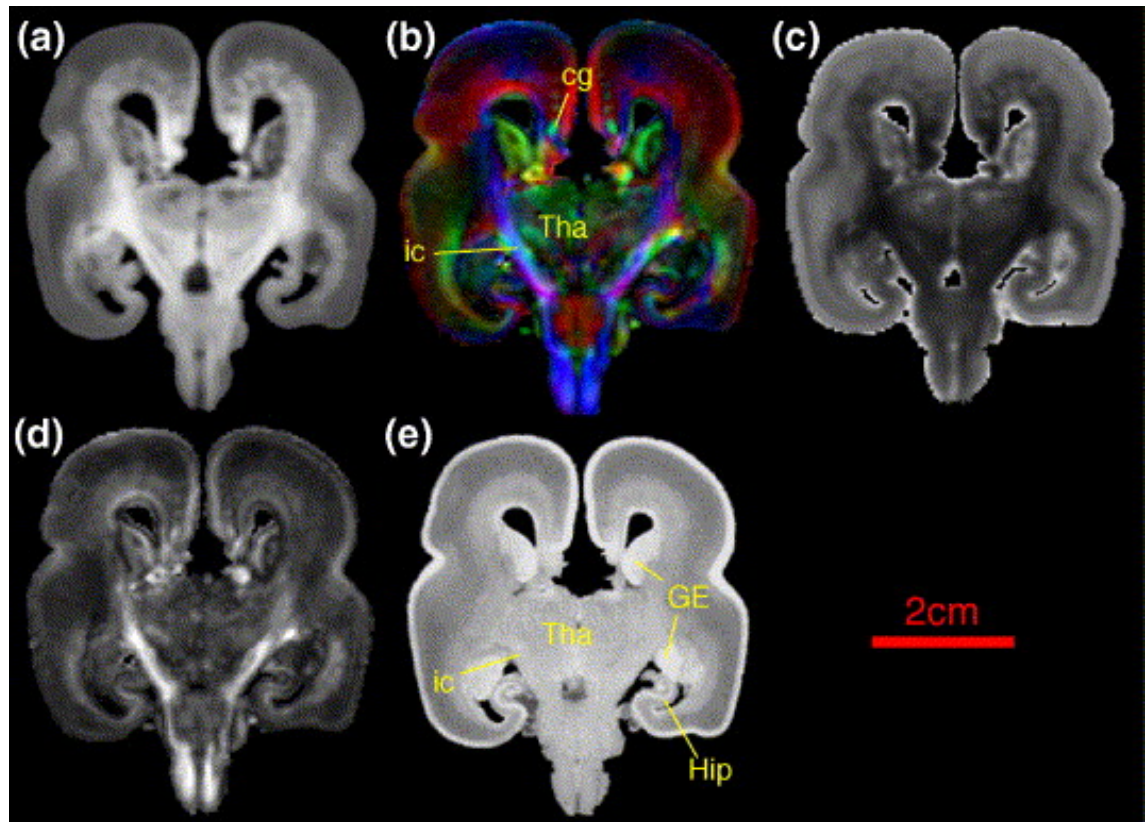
MRI of 19 gestational week post-mortem foetal brain. (a) Average diffusion-weighted image, (b) color-coded orientation map (red: right-left, green: anterior-posterior, blue: superior-inferior orientations), (c) ADC map, (d) FA map, and (e) T1-weighted image. Cg = cingulum; ic = internal capsule; GE = ganglionic eminence; Hip = hippocampus; Tha = thalamus. Image reproduced from Huang et al. (2006)
